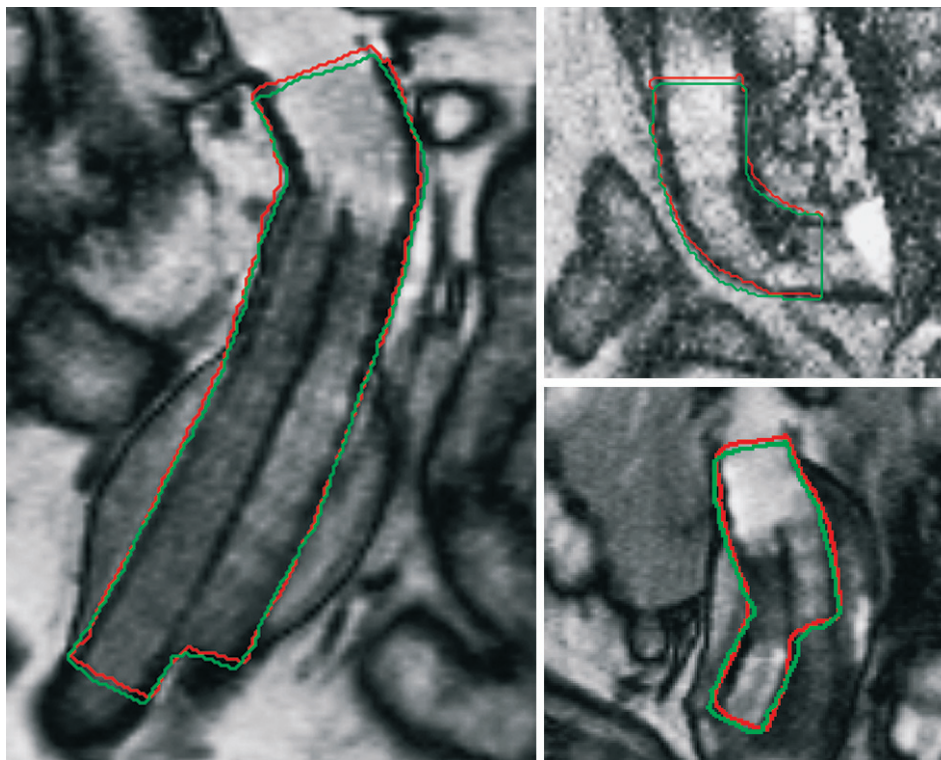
Cine MRI of stent-graft at peak-systole (green contour) and added red contour (end-diastole). Note the subtle bending of the stent-grafts at sites of maximal angulation.
